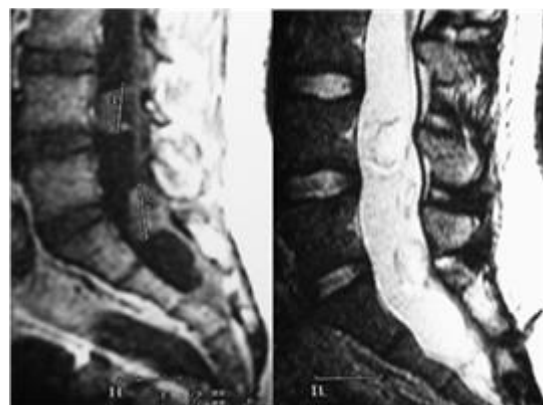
MRI of congenital dermal sinus with dermoid cyst at L₄–S₂ level sagittal T1 and T2 images
